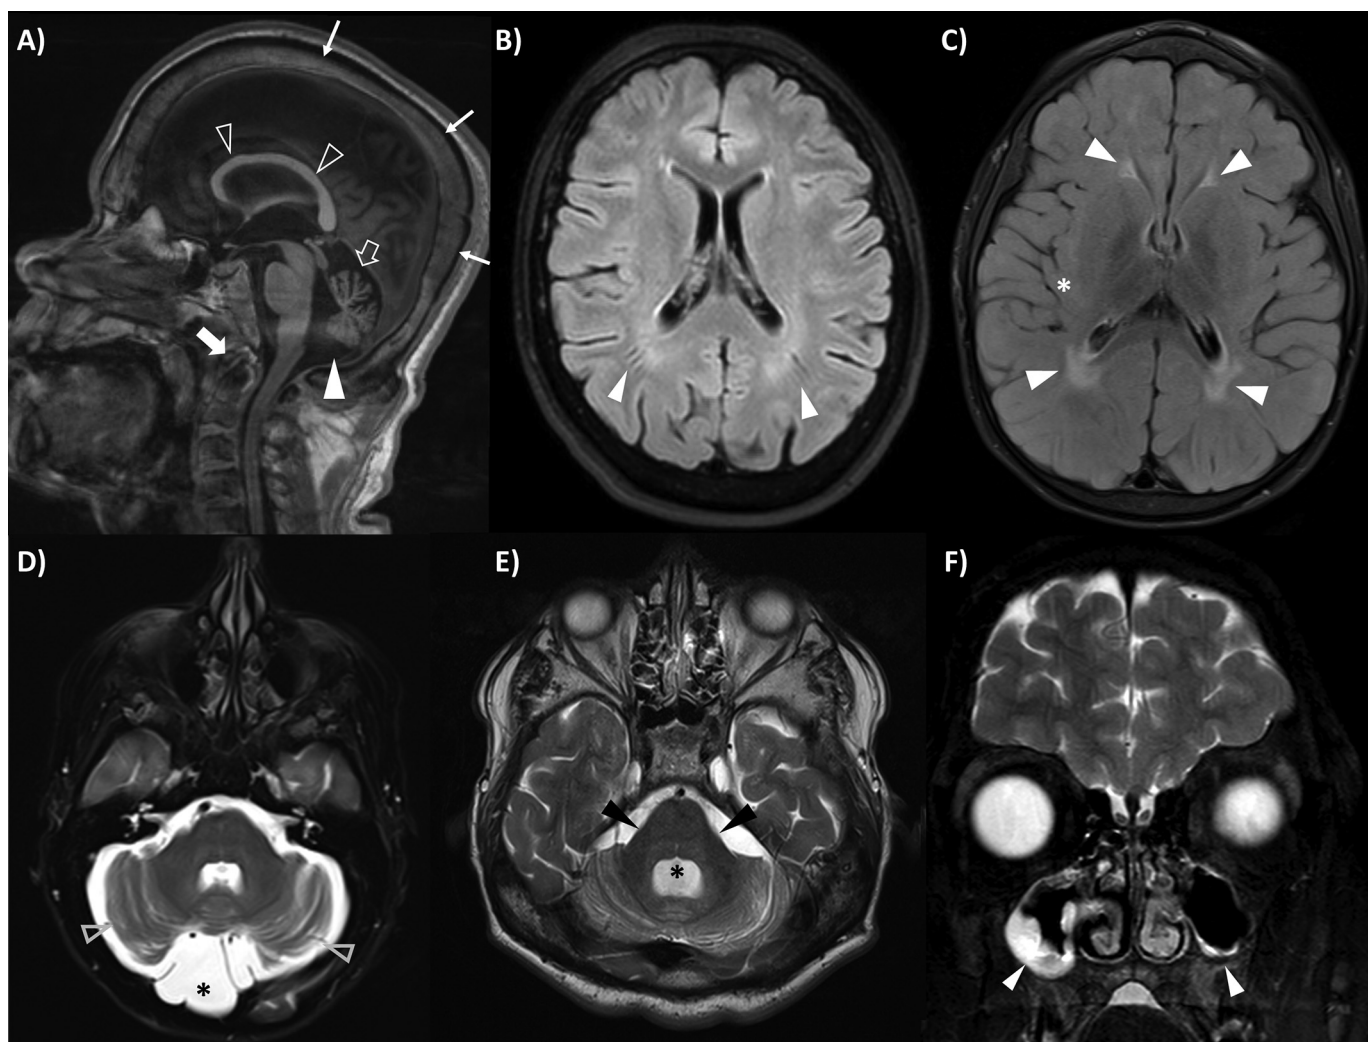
A representative example of typical brain MRI abnormalities in alpha-mannosidosis. A) Thin corpus callosum (open arrowheads) and cerebellar vermis atrophy (open arrow), enlargement of cisterna magna (white arrowhead), abnormal craniocervical junction due to dens dysplasia (thick white arrow), and diploic space thickening (thin white arrows) on mid-sagittal T₁w image. B) Enlargement of perivascular spaces on T₂-FLAIR (white arrowheads) images. C) Diffuse increase of T₂ signal with focal T₂ hyperintensities in the periventricular white matter (white arrowheads) on axial T₂-FLAIR image in a 6-year-old patient; note low contrast between cerebral gray/white matter and seemingly hypointense deep gray matter (white asterisk). D) Cerebellar atrophy (empty arrowheads) and retrocerebellar cyst (asterisk) on axial T₂w image. E) Cerebellar atrophy with middle cerebellar peduncle thinning (black arrowheads) and enlargement of the 4th ventricle (black asterisk) on axial T₂w image. F) Mucosal thickening and hypoplasia of maxillary sinuses (white arrowheads) on coronal T₂w image; note also low cerebral gray/white matter contrast.
